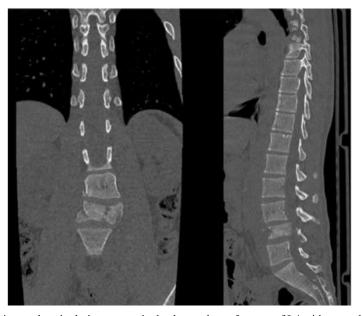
Preoperative CT coronal view and sagittal view respectively shows aburst fracture of L4 with more than¹/₃ of vertebral body height was affected.
